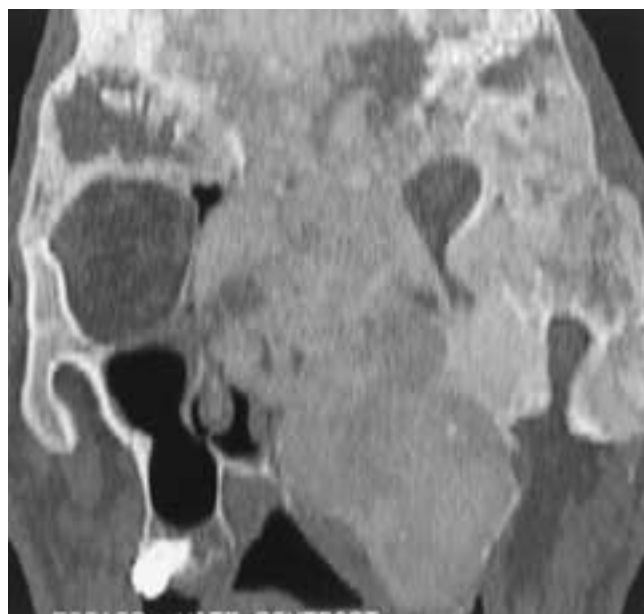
Diffuse skull and facial fibrous dysplasia. This coronal CT scan reveals the extensive involvement of the midface and left facial bones with obliteration of the left maxillary sinus, most of the nasal cavity, ethmoid, and frontal air cells, and severe left orbital encroachment. This pattern of severe facial bone involvement is termed *leontitis ostea*.
